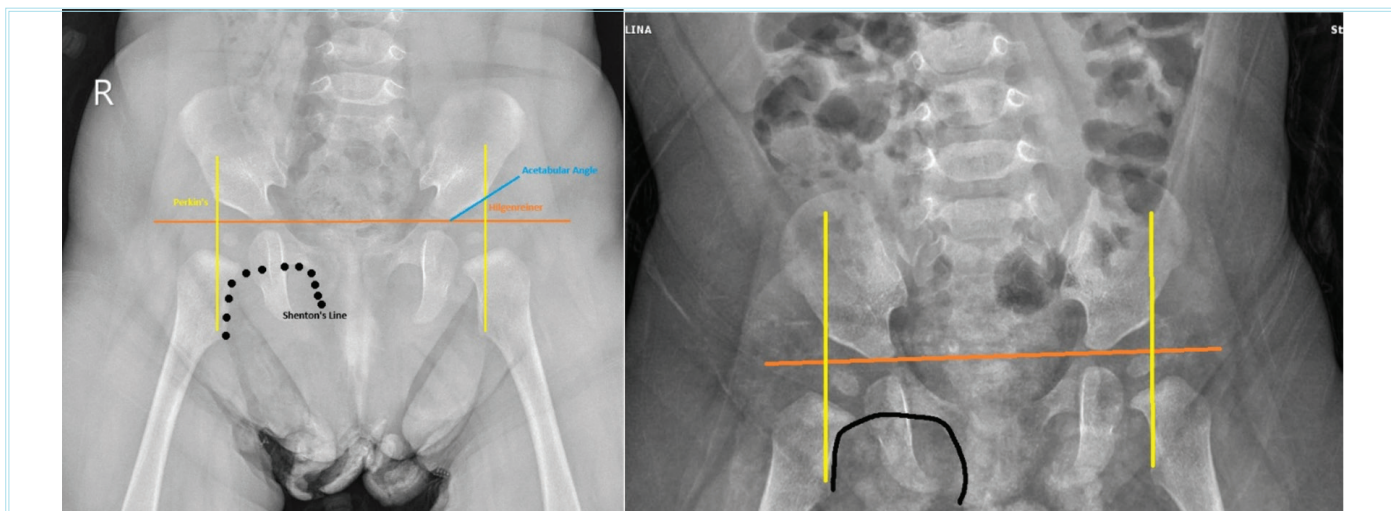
Representative anteroposterior pelvic radiograph demonstrating the radiographic assessment performed in the study. Anteroposterior pelvic radiograph of a certain month-old child showing the Hilgenreiner lines, Perkin lines, and the inferomedial quadrants used to evaluate femoral head position. The Shenton lines are preserved bilaterally. The right and left acetabular angles are measured between the Hilgenreiner line and the acetabular roof line extending from the triradiate cartilage to the lateral acetabular margin. The anatomical landmarks and measurement lines used for calculation of the acetabular angles are indicated
